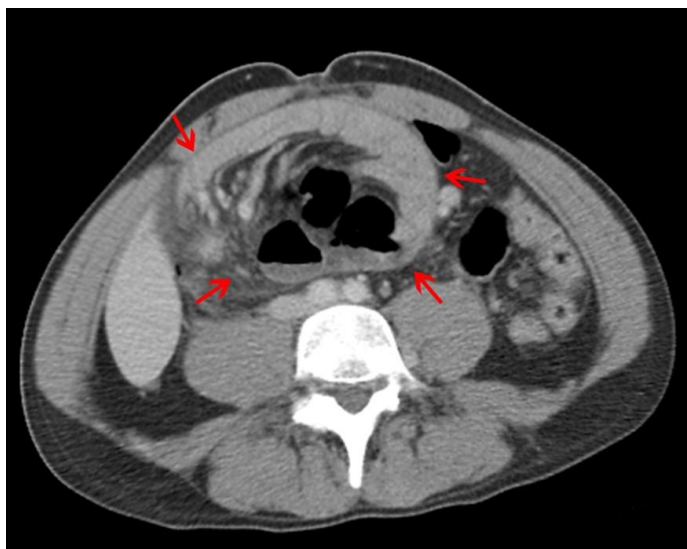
A computed tomography section showed a portion of the transverse colon and dilated mesenteric vascular structures (arrows).
